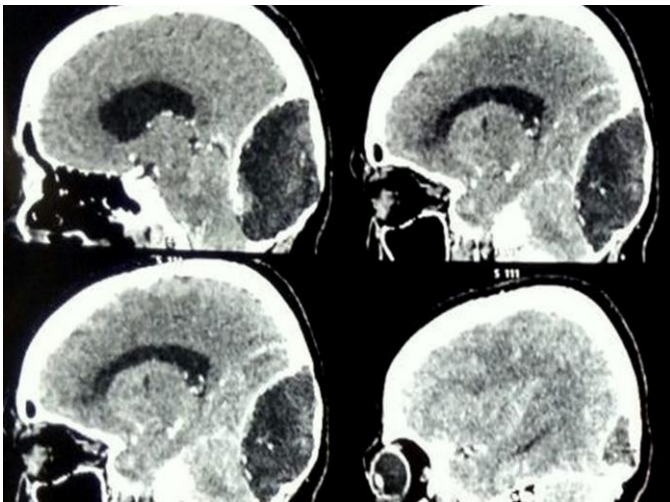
CT brain showing enlargement of the diploic space with erosion of inner table and scalloping.
